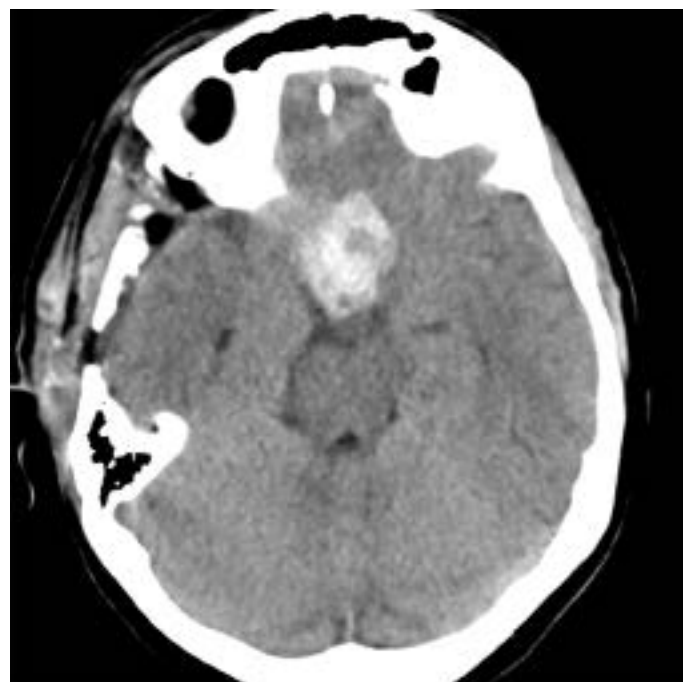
An Axial CT Scan Showing Hemorrhagic Infarction at Surgical Site
